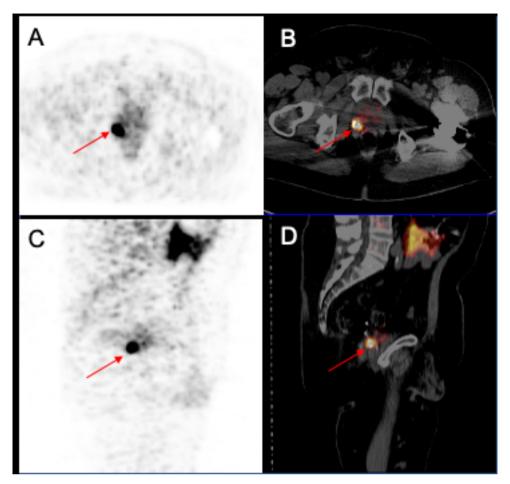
68-year-old patient, previous radical prostatectomy, Gleason grade 3, PSA before PET 2.7ng/ml. Axial ¹⁸F-1007-PSMA PET (A) and fused (B) images demonstrating prostatic recurrence (arrow). Sagittal ¹⁸F-1007-PSMA PET (C) and fused (D) images demonstrating prostatic recurrence (arrow).
